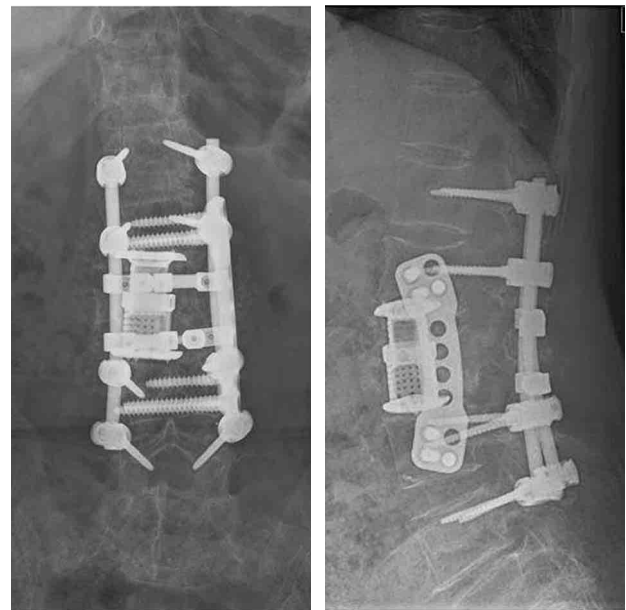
Postoperative plain radiographs showing the reconstructed lumbar spine.
